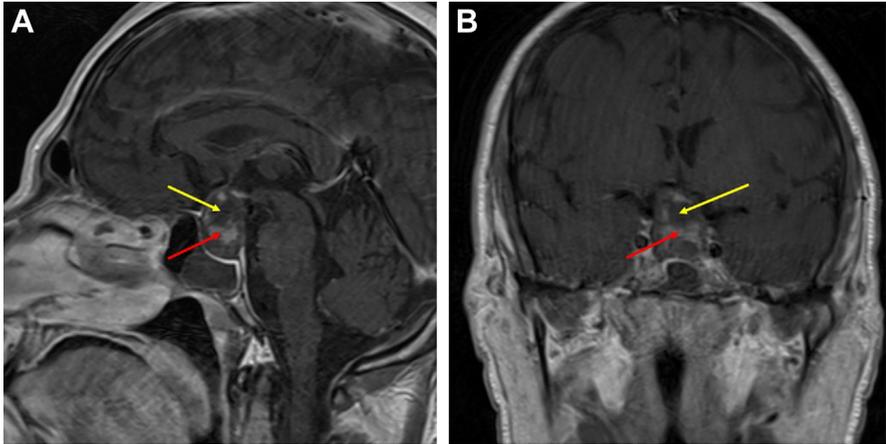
Apoplexy case example. (A) Sagittal and (B) coronal MRI T1 scan with contrast images demonstrating a macroadenoma with suprasellar extension and acute hemorrhage within the tumor. The pituitary tumor extended superiorly to compress the optic chiasm and abutted the floor of the third ventricle. The sella demonstrated heterogeneous intensities, with enhancing areas of macroadenoma (red arrows) and iso-intense areas representing hemorrhage (yellow arrows).
